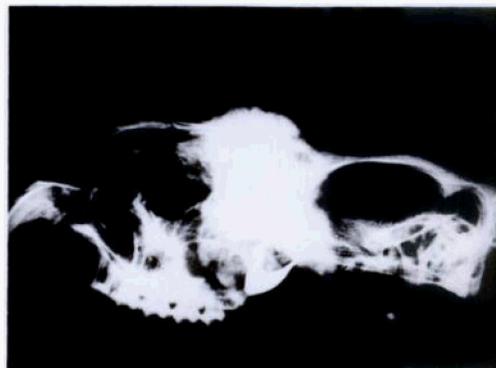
Lateral radiographic view of the skull of koala B showing a dense tumorous mass, with a brush-like or fine spicular periphery.
